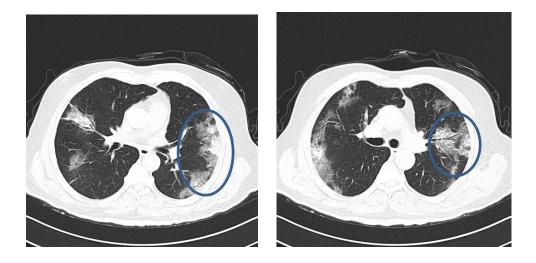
CT scan images of 55-year-old male with positive RT-PCR. Axial thinsection CT scan shows bilateral subpleural patchy ground-glass pulmonary opacity. (Z. Cheng et al., 2020)
